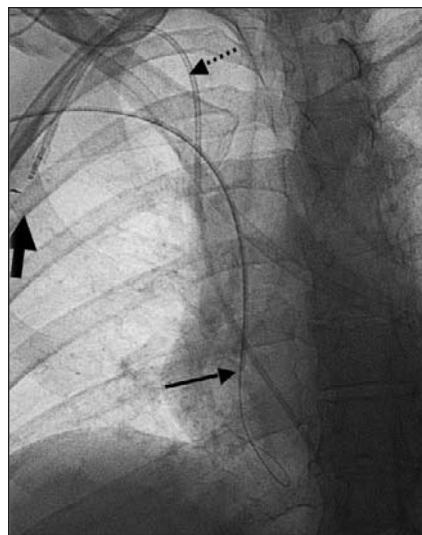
Radiograph showing the plastic reservoir of the subcutaneous port (fat arrow). The catheter tip is positioned deep within the right atrium (dotted arrow), and the tip of the peripherally inserted central catheter line is in the mid right atrium (arrow).
